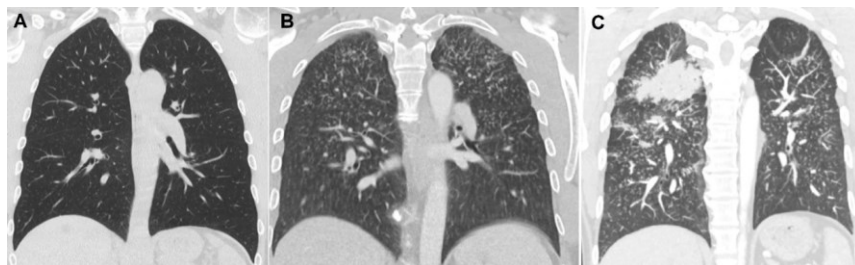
(A) Chest CT scan of a patient with normal lungs; (B) a patient with simple chronic silicosis; (C) a patient with progressive massive fibrosis [source: UZ Leuven patients].
